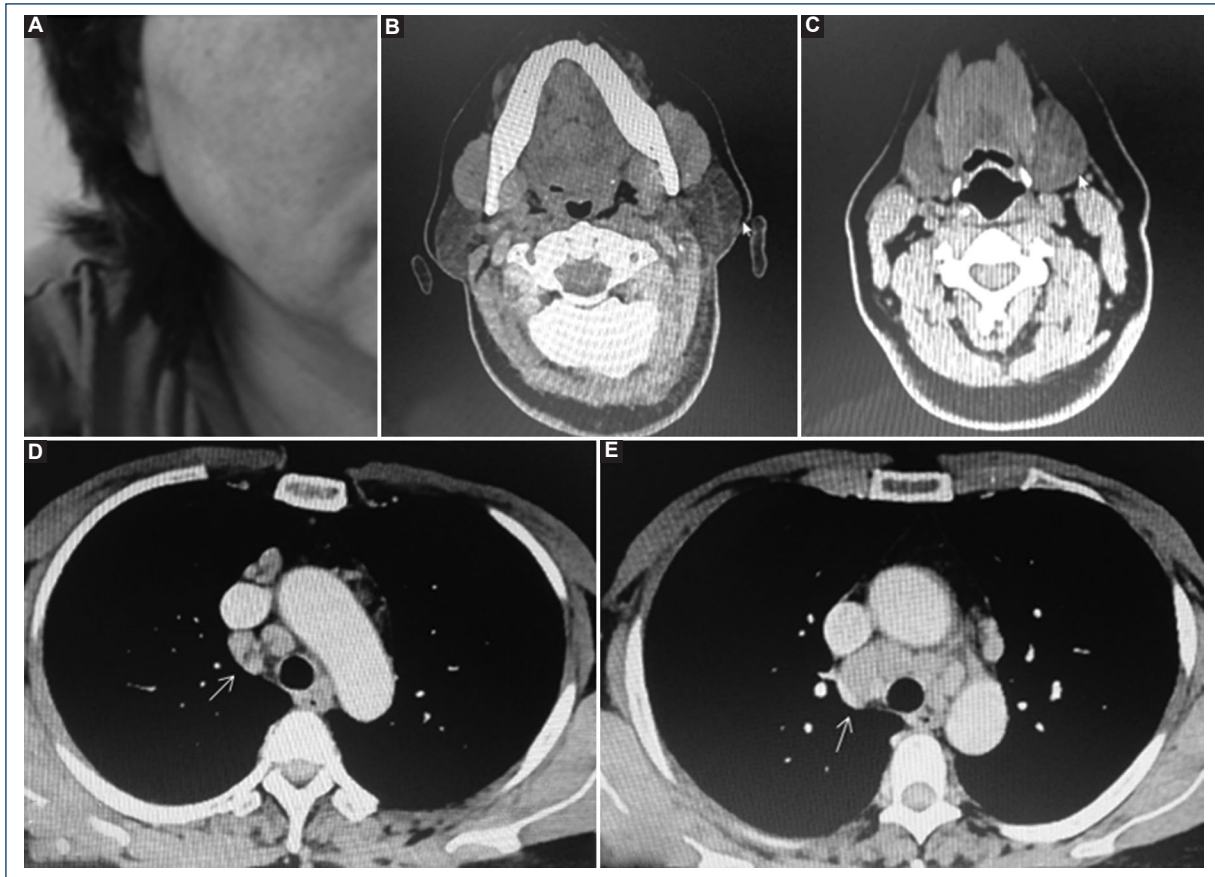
A: swelling of the right parotid region. B: computed tomography (CT) scan of the neck showing hypertrophy of both parotid glands. C: CT of the neck indicating hypertrophy of the submaxillary glands. D: CT of the chest (mediastinal window) in which right paratracheal nodes are indicated. E: CT of the chest showing retrocavaortic and subaortic peritracheal mediastinal nodes.
